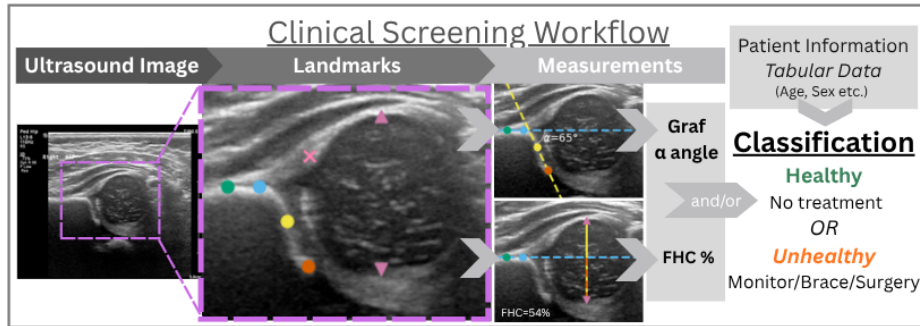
DDH Screening. Landmarks on ultrasound images used to calculate the α angle and FHC %. The iliac points (green/blue), turning point (yellow), lower limb point (orange), labrum (pink), and upper and lower femoral head (purple) are shown. The α angle: measured between the iliac baseline (blue) and bony roof line (yellow). The FHC %: calculated as the acetabular depth (d , orange dashed) divided by the femoral head diameter (D , yellow solid). These measurements are combined with clinical data to classify patients (healthy/unhealthy).
